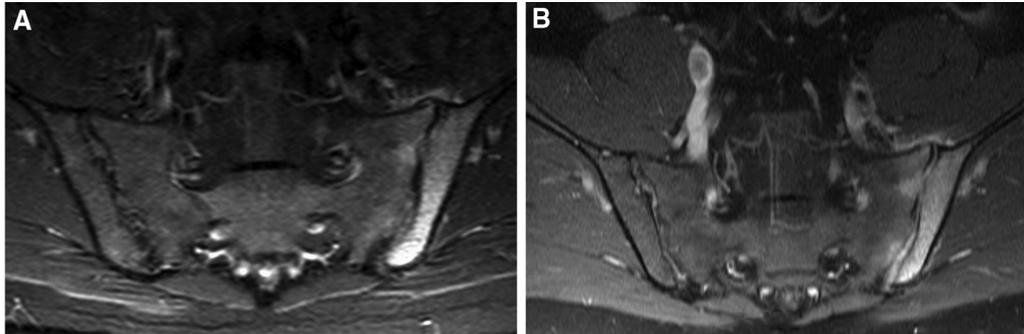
Acute left sacroiliac joint pain in a previously well patient without constitutional symptoms. (A) Axial short tau inversion recovery image shows unilateral bone marrow oedema surrounding the left sacroiliac joint consistent with unilateral sacroiliitis. (B) Marked enhancement is seen on T1-weighted postcontrast sequences. Appearances were initially highly concerning for infection and aspiration was performed but yielded no organisms on microbiological analysis. A diagnosis of reactive sacroiliitis was made following exclusion of other causes.
